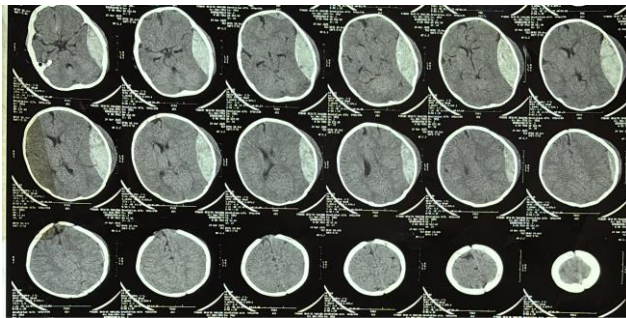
Non-contrast CT head on admission, showing a massive right frontotemporoparietal biconvex extradural hematoma (~100 mL, $11 \times 5 \times 3$ cm) with only 3 mm of midline shift.
